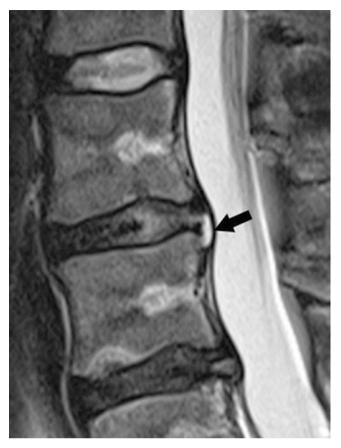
Sagittal MRI images of lumbar spine shows disc degeneration with decrease in signal intensity at L2–L3 and L3–L4 when compared to L1–L2. Also pictured at L2–L3 is a posterior hyperintense zone (HIZ) (arrow). (Reprinted by permission from Springer Nature: Imaging of Degenerative Disk Disease by Guillaume Bierry, Jean Louis Dietemann. Copyright 2016)
